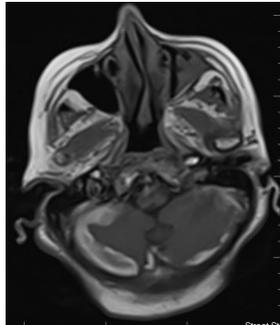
T1-weighted MRI demonstrate depicts the subdural haematomas which are much more pronounced on the right side
